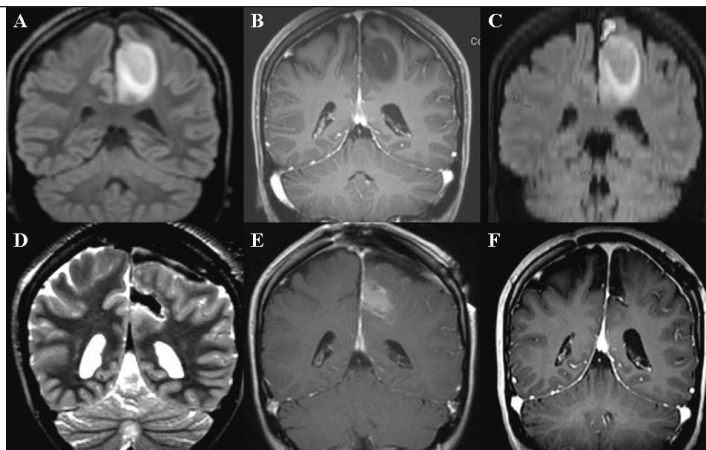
A 27-year-old, right-handed female presenting with simple partial seizures consisting of intermittent right leg tingling and dyscoordination. MRI of the brain demonstrated a lesion in the left posterior frontal lobe that was hyper-intense in T2-weighted imaging (A) and hypo-intense on T1-weighted imaging without significant gadolinium enhancement (B). Functional MRI using a toe-taping paradigm (C) demonstrated that the lesion was under the motor cortex for the right leg. The patient underwent an IoMRI-guided craniotomy for surgical resection. IoMRI scans, T2-weighted (D), and T1-weighted with contrast (E) demonstrated radiographically complete resection. Post-operatively, the patient experienced a mild right foot drop that resolved within three months. Surgical pathology was consistent with a WHO Grade II glioma. Two-year post-operative scan (F) demonstrated no evidence of recurrent disease.
